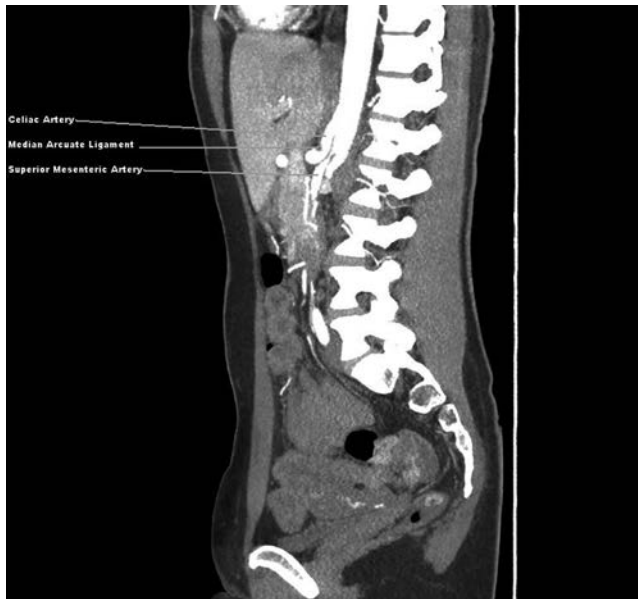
Sagittal view of the computed tomography angiography showing compression of the celiac artery. (Republished with permission of Lainez RA, Richardson WS. *Ochsner J.* 2013;13(4):561–4.²³)
